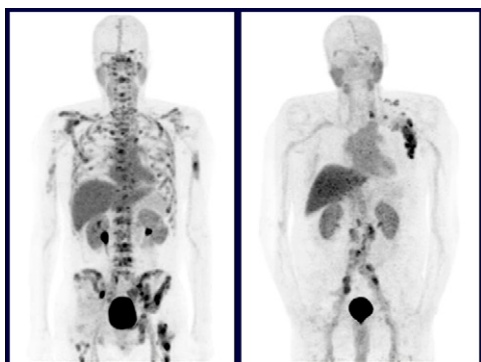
PSMA-targeting ^{18}F -DCFBC PET images demonstrating (left) widespread bone metastases in a patient with castration-resistant prostate cancer and (right) nodal metastases (supraclavicular, axillary, retroperitoneal) in a patient with castration-sensitive prostate cancer.
